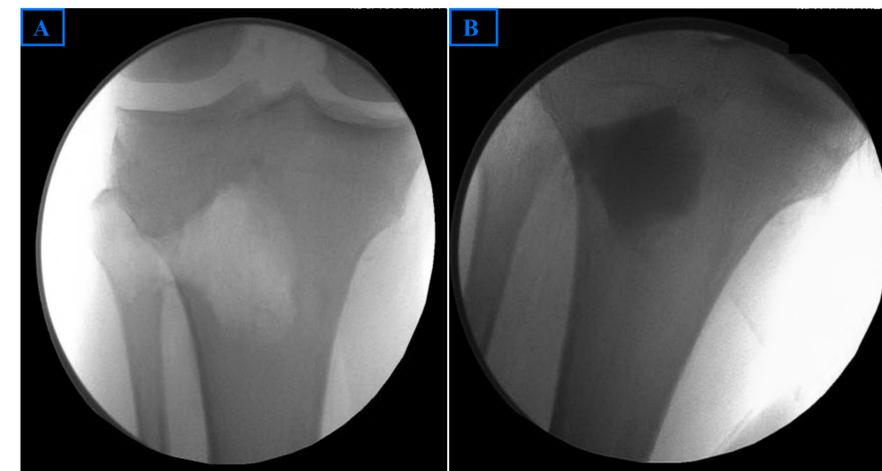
A) AP radiograph of the proximal tibia post-bone graft harvest. B) Radiograph of the proximal tibia bone graft harvest site backfilled with bone substitute.
